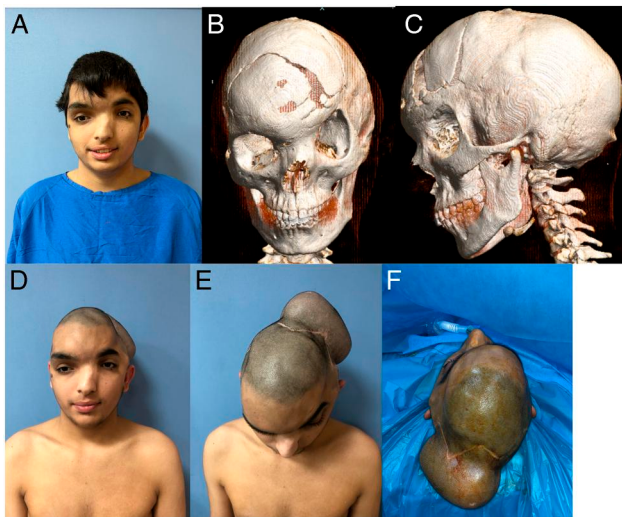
(A) Preoperative anterior view. (B) 3D CT anterior view. (C) 3D CT lateral view. (D) After tissue expander anterior view. (E) After tissue expander upper view. (F) Upper view before implant surgery.
